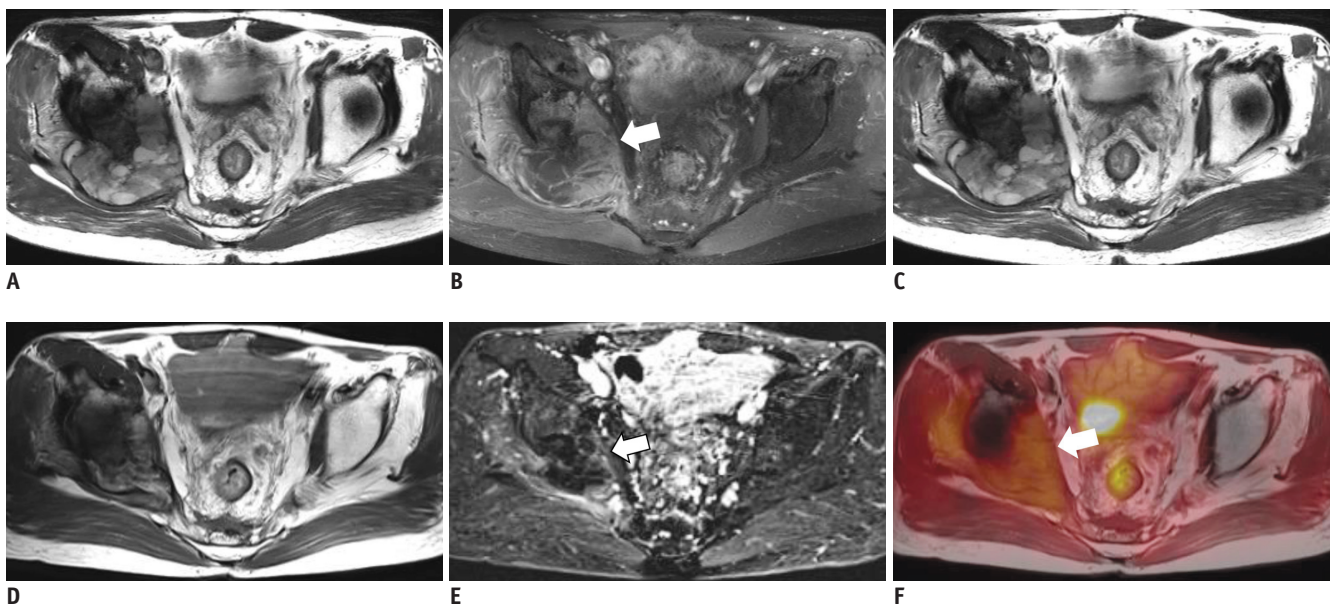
53-year-old male with radiation-induced osteosarcoma in right ilium before (A-C) and after (D-F) chemotherapy. A. Axial, T2-weighted MR image showed heterogeneous, T2 hyperintense soft-tissue mass in right ilium. B. Axial, post-contrast, T1-weighted MR image showed soft-tissue enhancement (arrow) with central non-enhancement before chemotherapy. C. Axial PET-CT image demonstrated increased FDG uptake (SUVmax = 21.84) in corresponding lesion. D. Axial, T2-weighted MR image obtained after chemotherapy shows decrease in tumor size. E. Axial, post-contrast, T1-weighted MR image obtained after chemotherapy shows decrease in area of soft-tissue enhancement (arrow). F. Corresponding to fused FDG-MR/PET image obtained after chemotherapy and which showed no pathological FDG uptake (SUVmax = 2.23). FDG = fluorodeoxyglucose, MR/PET = magnetic resonance imaging/positron emission tomography, SUVmax = maximum standardized uptake value
